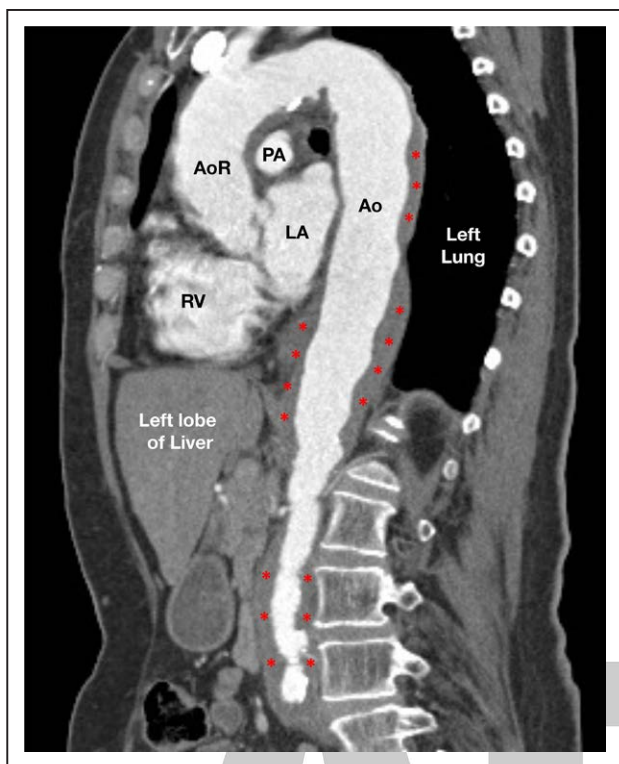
Computed tomography (CT) angiography in large vessel vasculitis (LVV). Coronal oblique multiplanar reconstruction contrast-enhanced CT with angiography demonstrating diffuse mural thickening of the thoracic and abdominal aorta (Ao; red asterisks) in a patient with LVV. AoR indicates aortic root; LA, left atrium; PA, pulmonary artery; and RV, right ventricle.
